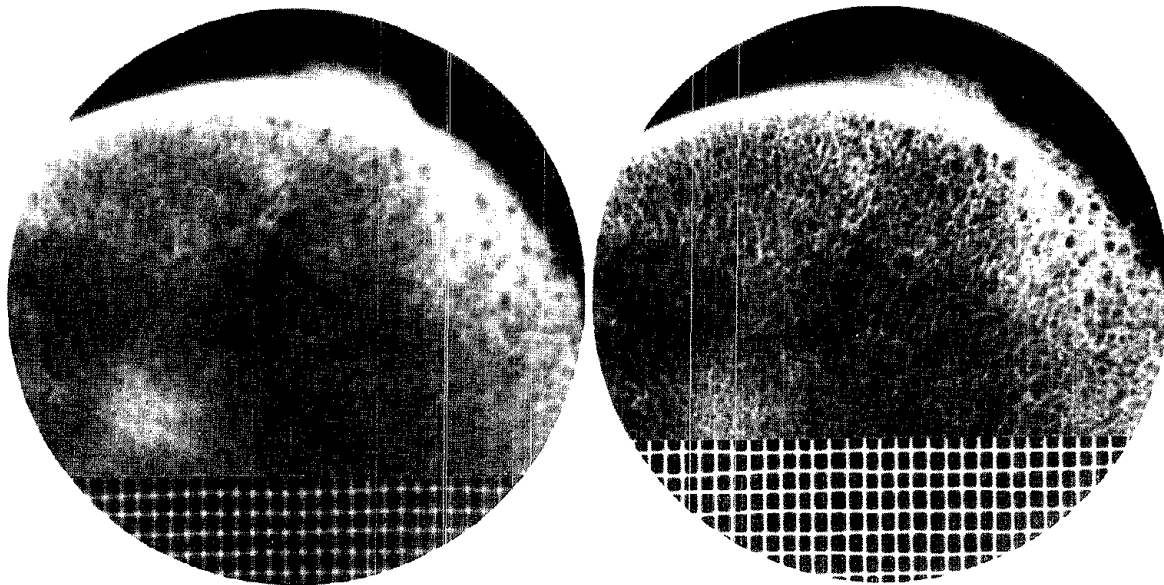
Radiographs showing the effect of poor screen-film contact. Figure 2A (left): Blurring of the image and loss of detail of the wire mesh and adjacent bone caused by poor contact. Figure 2B (right): Good contact between screens and film with sharp outlines of wire mesh and osseous structures.
